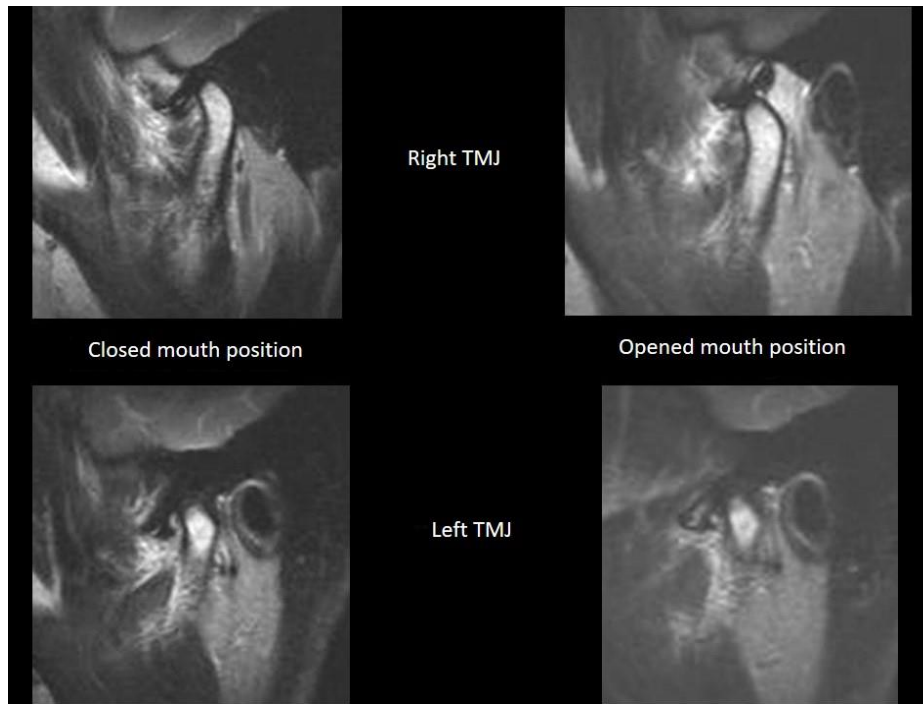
Turbo spin-echo T2-weighted MRI with parasagittal scans: top images of the right TMJ, bottom images of the left TMJ; left with mouth closed and right with mouth open.
